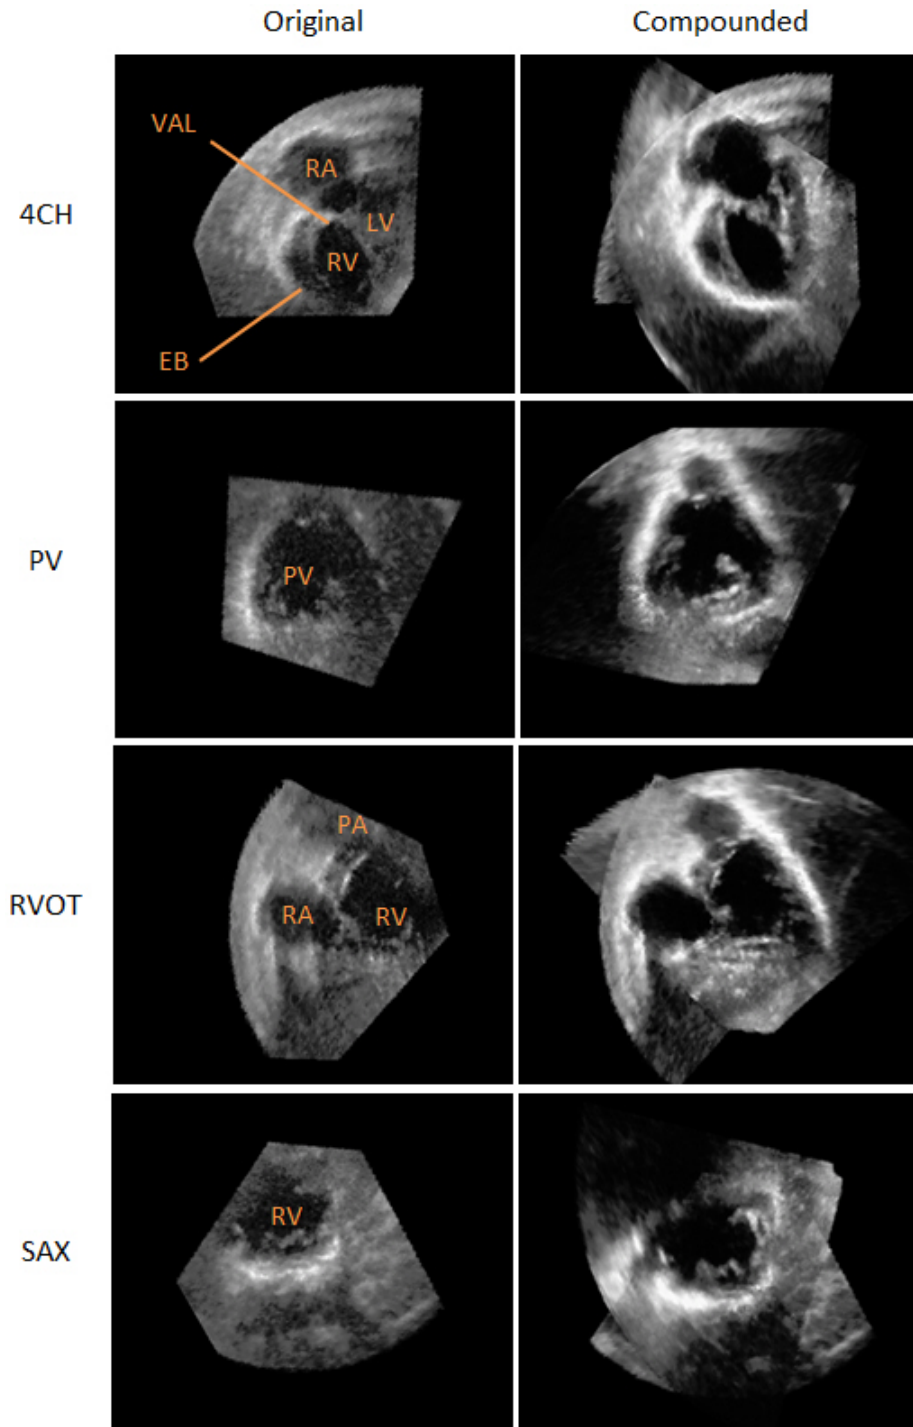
Slices from 3D echo images on HLHS1 patient data. Original and compounded images are presented in the following view angles: 4CH (apical four chamber), PV (pulmonary valve), RVOT (right ventricle outflow track) and SAX (short axis). My compounded images shows less noise, more contrast and with RV and PV well presented in single volume. (LV = left ventricle; RV = right ventricle; RA = right atrium; PA = pulmonary artery; EB = endocardial border; VAL = valve)
